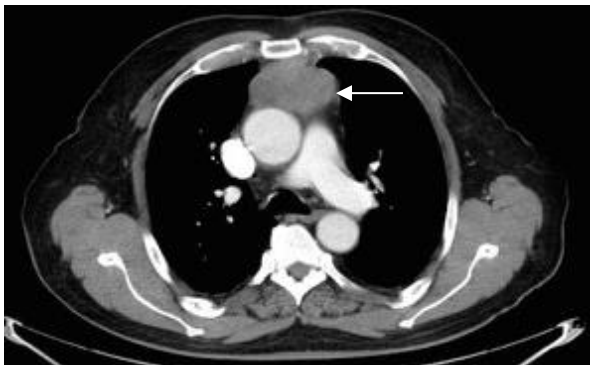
Computed tomography image of the patient showing a well-defined anterior mediastinal mass (arrow) within the thymus area
